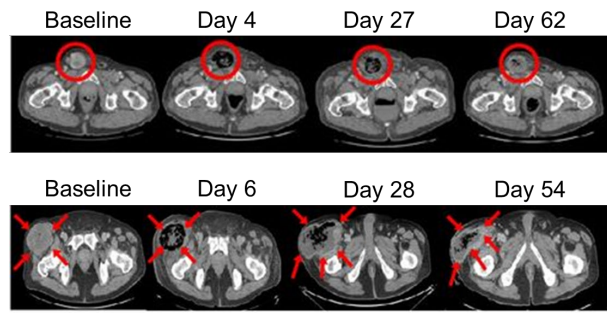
Computed tomography scans of patients treated with *C. novyi*-NT. Evidence of necrosis and gas pocket formation was observed. Reproduced from Roberts *et al.* (35).
